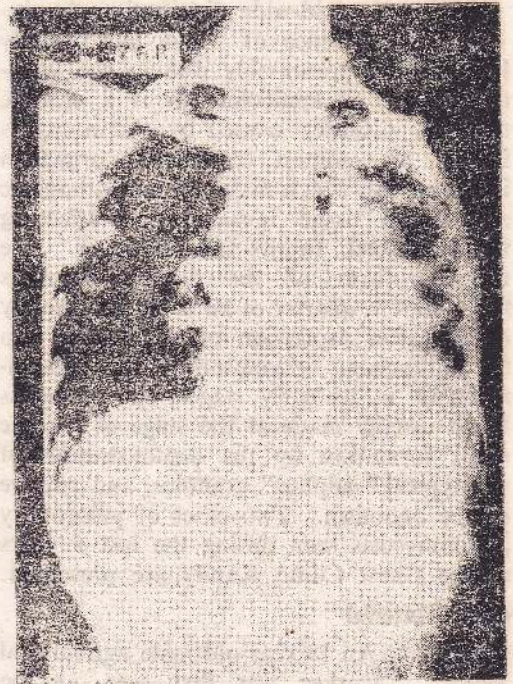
Case 1. Xray of the chest of 5-4-76 showing; high left leaf of the diaphragm, crowding of the left 2nd to 6th ribs, periosteal thickening of the left 4th, 5th and ribs, pleural effusion and opacity in the left mid and lower zones.
